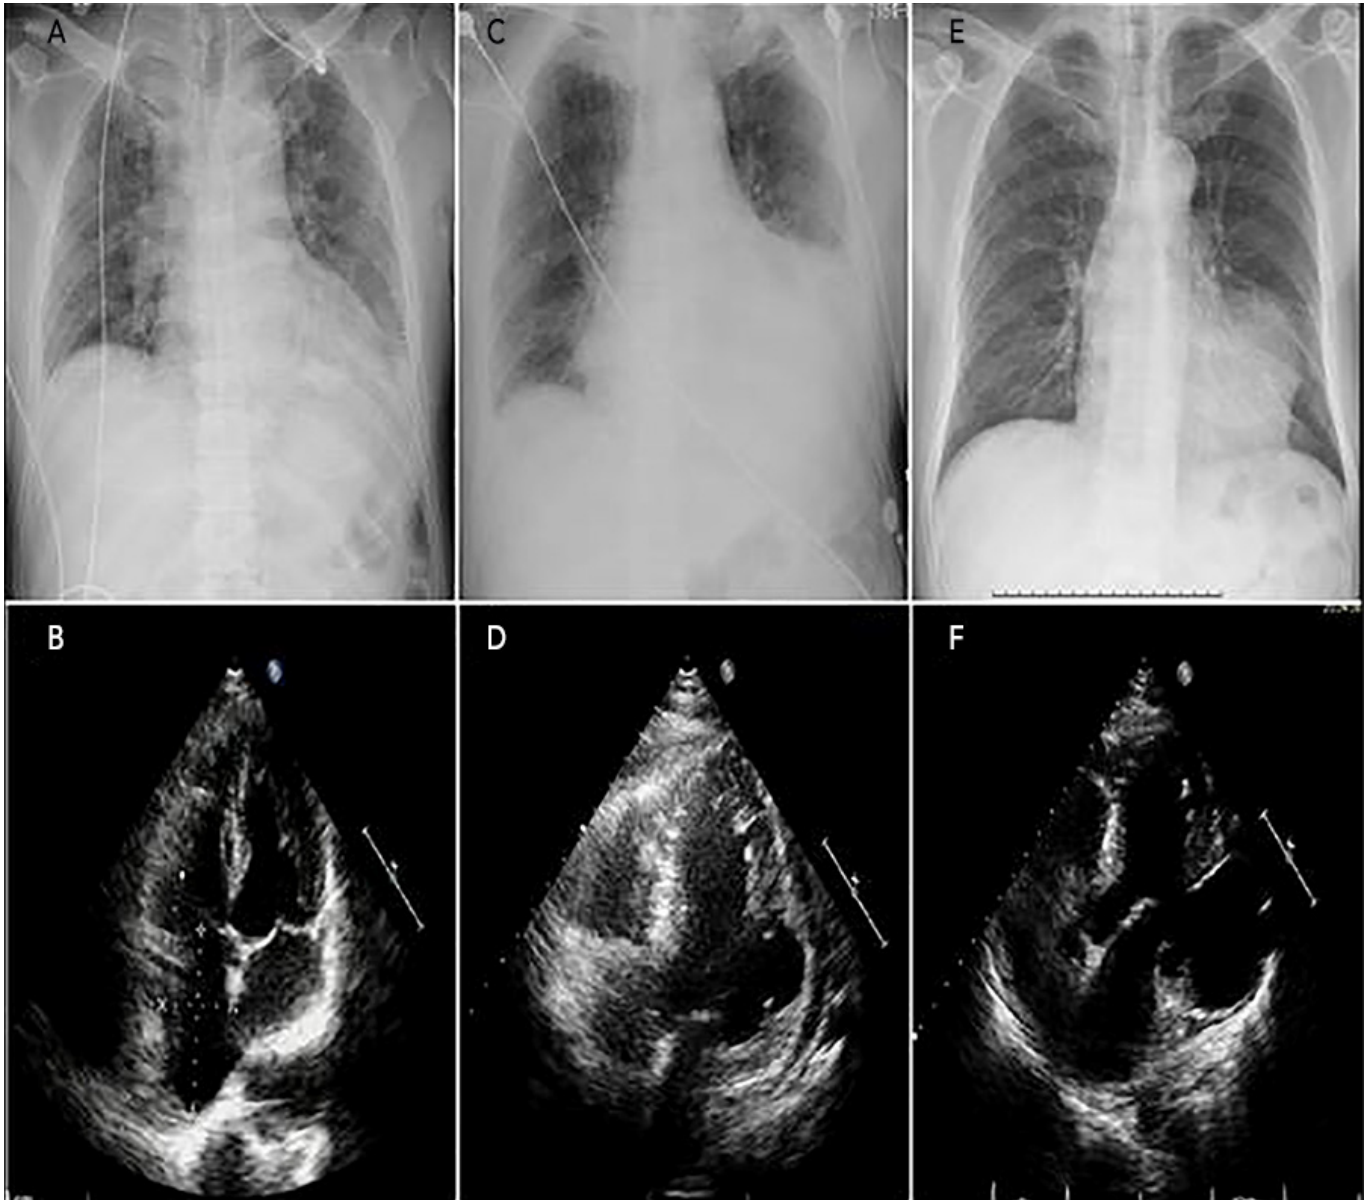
A) Chest X-ray revealing normal heart at admission. B) Two-dimensional transthoracic echocardiography (TTE) demonstrating akinesis in the posterolateral wall with no other clinically significant abnormalities. C) Chest X-ray revealing an enlarged heart and a mild left pleural effusion after 11 days of the acute episode of MI. D) Two-dimensional TTE showing a left ventricular aneurysm of the posterolateral wall (approximately 1.5 X 2.6 cm). E) Chest X-ray showing cardiomegaly, pulmonary congestion, and a localized tortuous aorta after 26 days of the acute episode of MI. F) Repeated TTE revealed a giant (approximately 6.4 X 5.4 cm) LV pseudoaneurysm in the posterolateral pericardial space that communicated with the left ventricle through a 2.4 cm cavity in the posterolateral left ventricular free wall.
